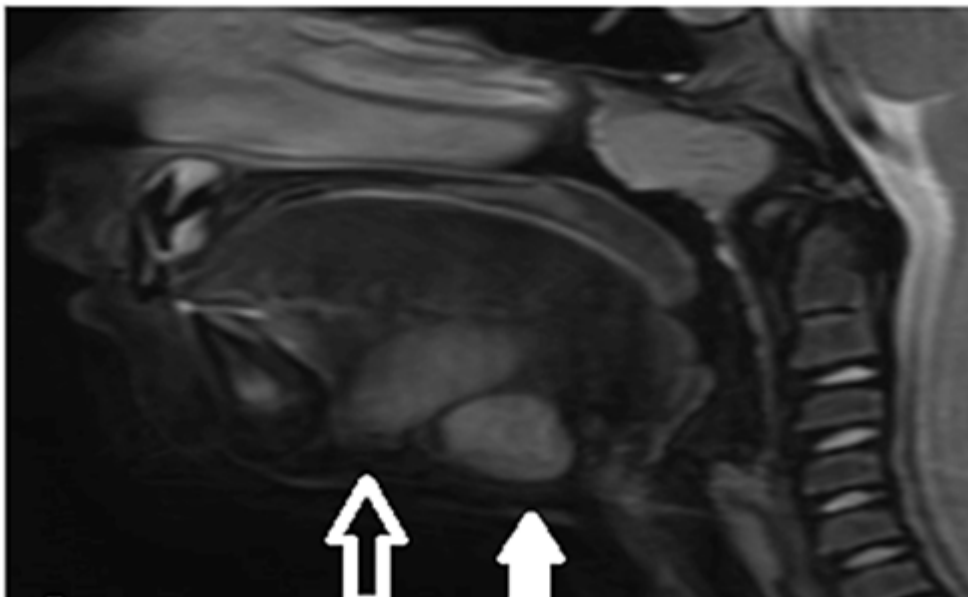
Sagittal T2 MRI demonstrating relative positions of both dermoid lesions (submental space mass: solid arrow, lingual mass: clear arrow).
